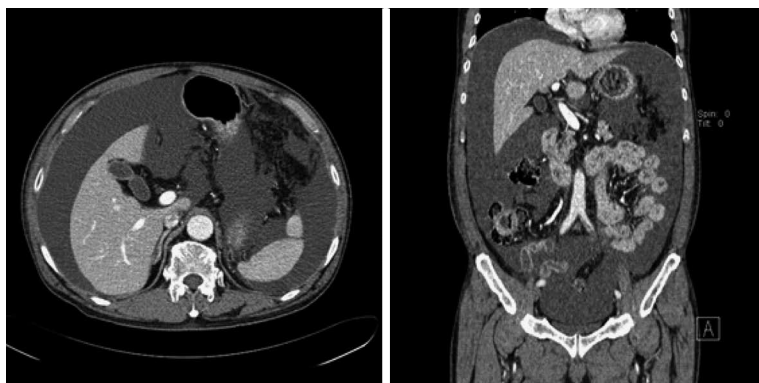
Abdominal computed tomography images showed a large volume of ascites.
